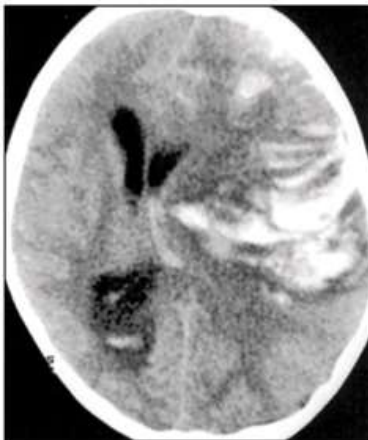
CT scan demonstrates a large ill-defined hematoma in left frontal and temporal lobes, with extension into the ventricles and severe midline shift.
